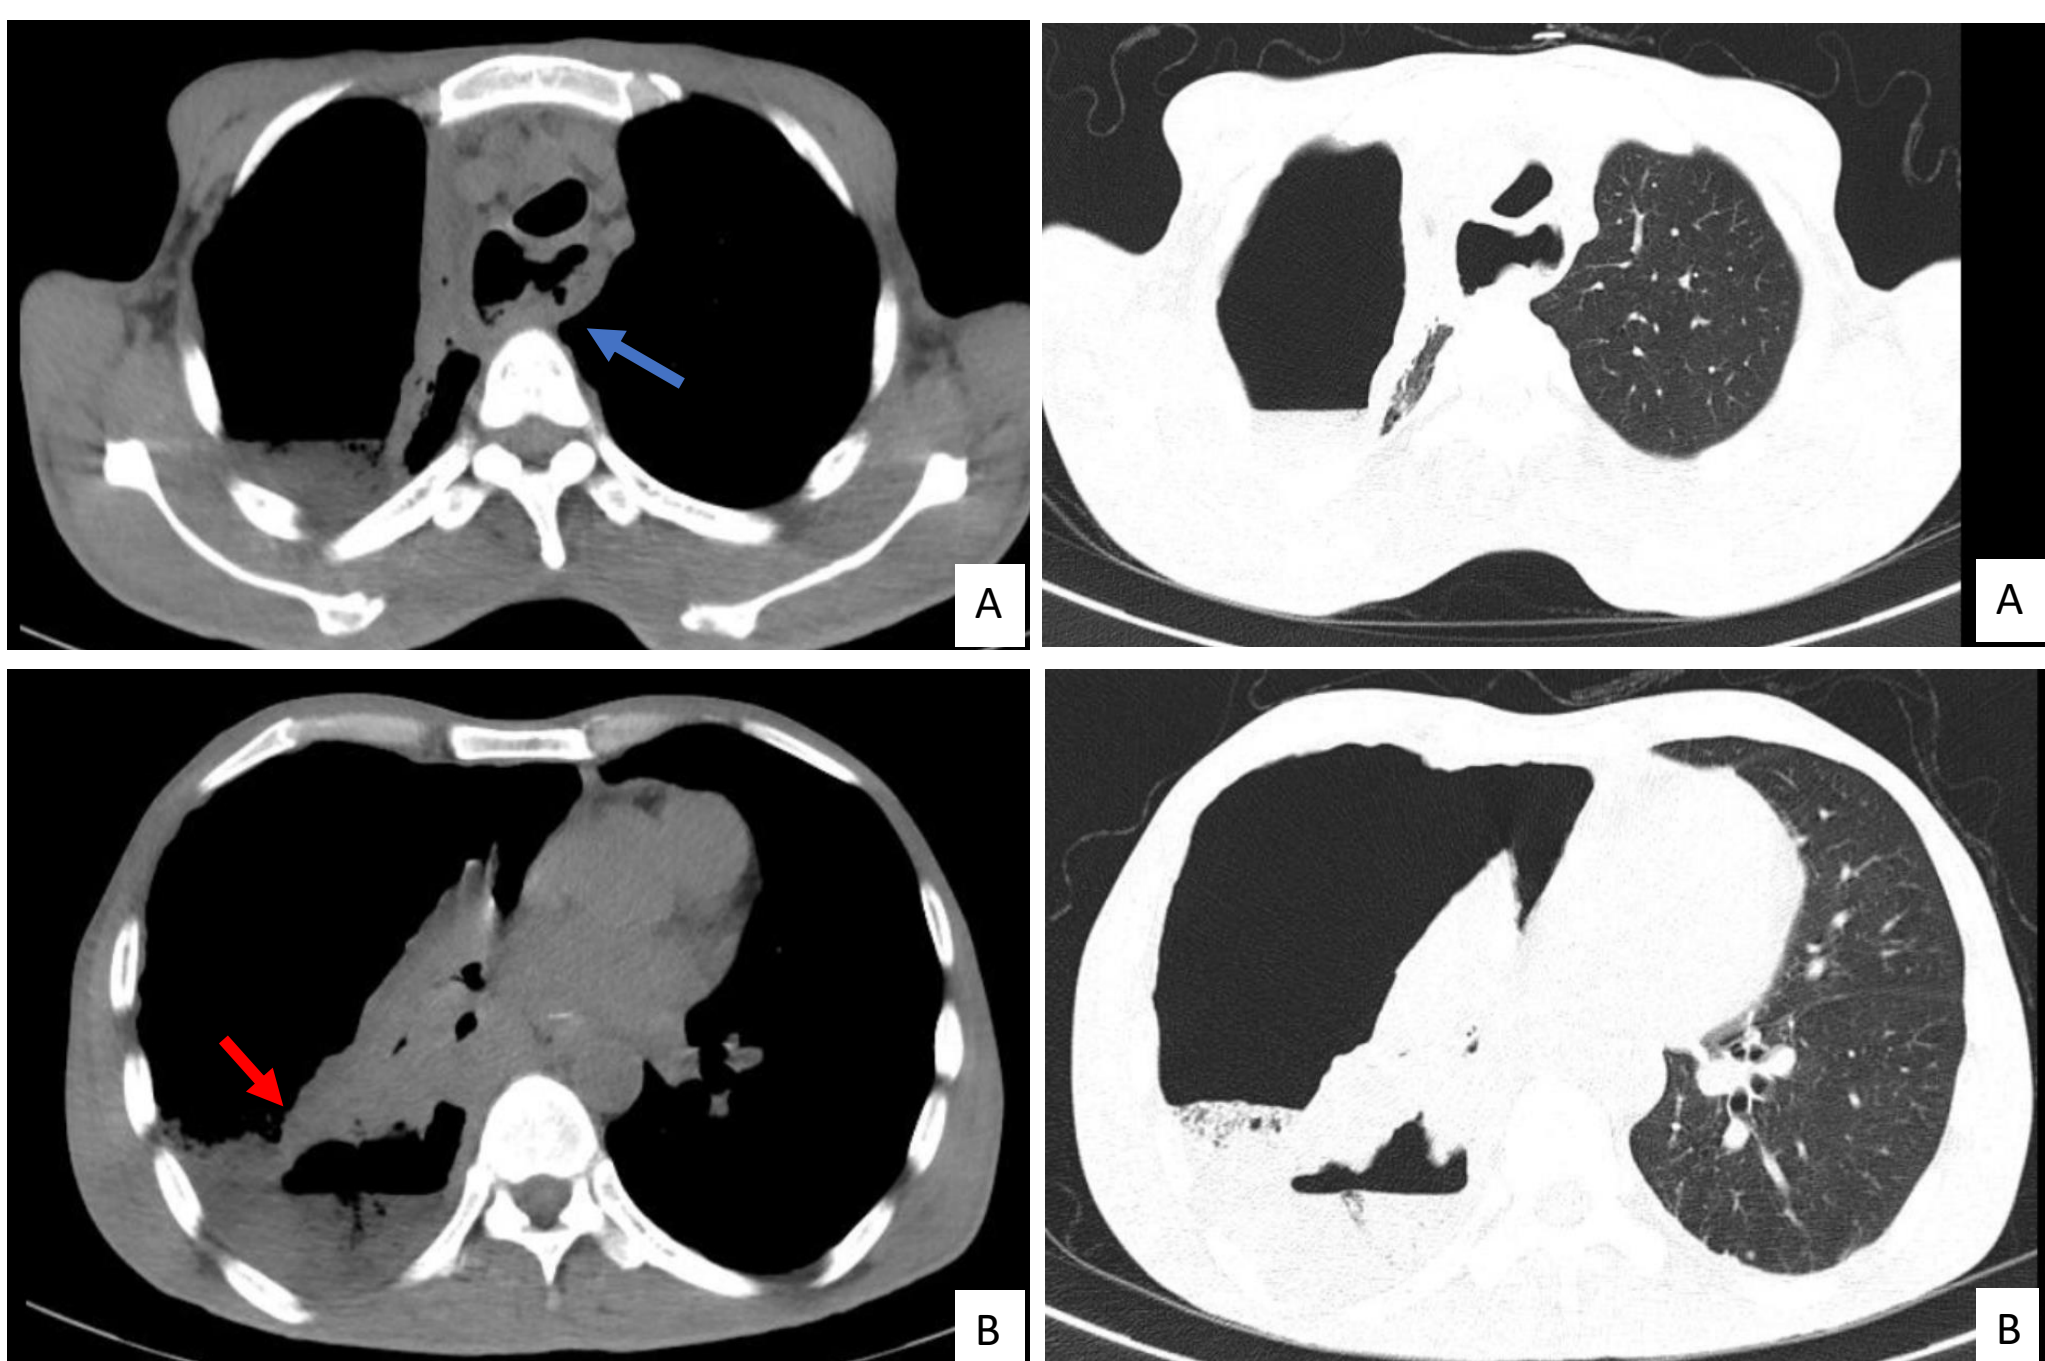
A) Chest CT scan, red arrow: esophageal dilatation. B) Blue arrow: right lung abscess.
